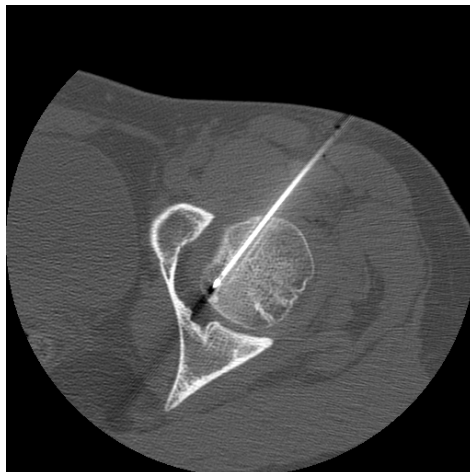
Biopsy needle positioning confirmed on CT.
